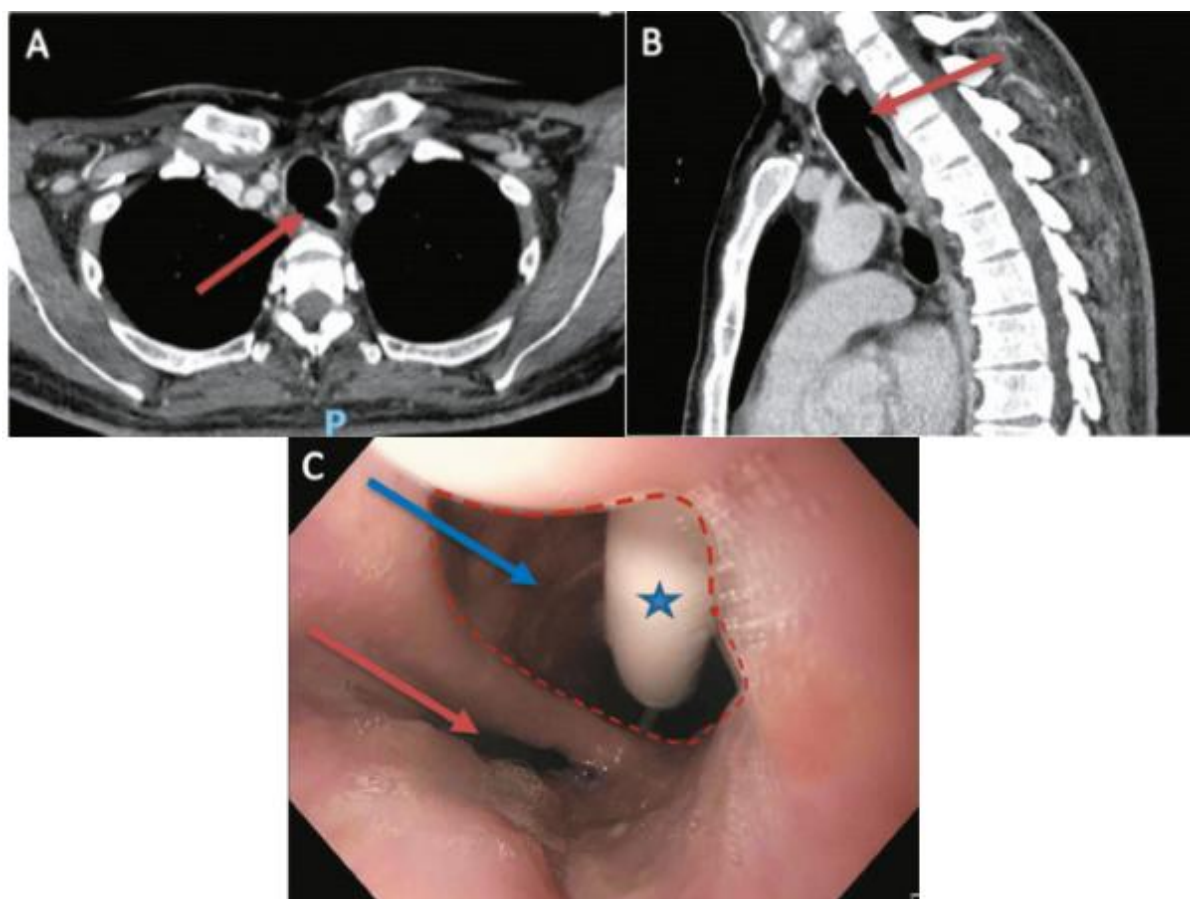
Courtesy ref no-45-Iatrogenic tracheoesophageal fistula after emergency orotracheal intubation. Computed Tomography (CT) images showing a large tracheoesophageal fistula (red arrow) in axial (a) and sagittal plane (b). Endoscopic image (c) of the fistula (red dashed line) between esophageal lumen (blue arrow), with a nasogastric tube inside (blue star), and tracheal lumen (red arrow).
